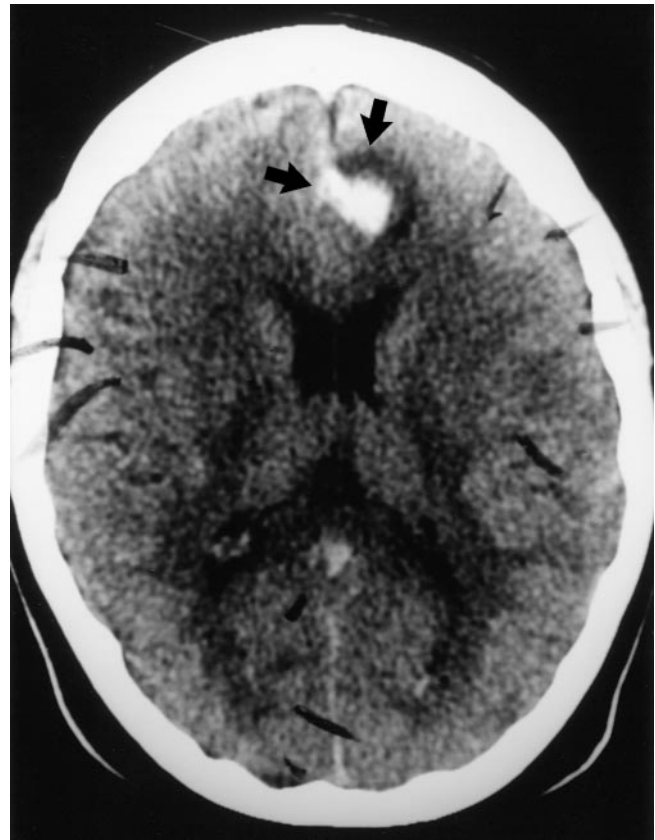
Unenhanced CT scan of the brain shows an approximately 2-cm area of hyperdensity surrounded by hypodensity in the inferior left frontal lobe (arrows). This represents an area of hemorrhage and surrounding ring of edema.
